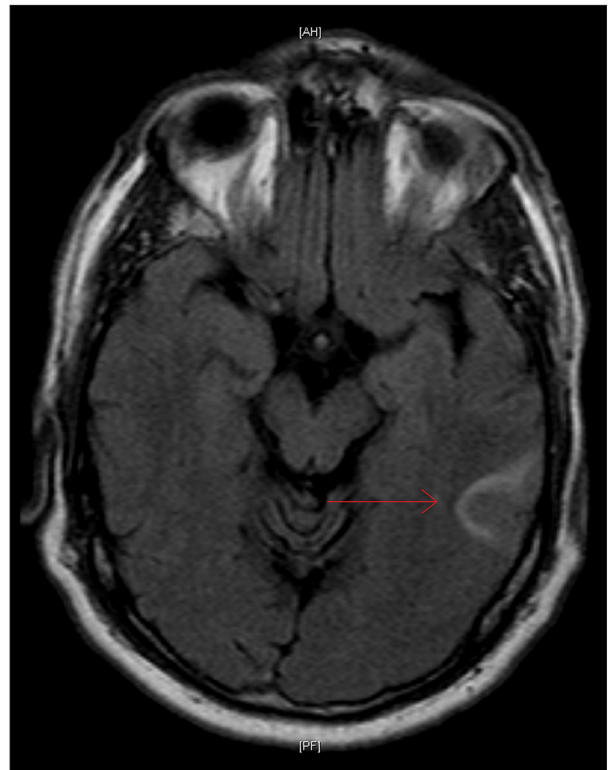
Axial FLAIR MRI reveals hyperintensity consistent with left temporal lobe edema (arrow) and small linear hemorrhages.
